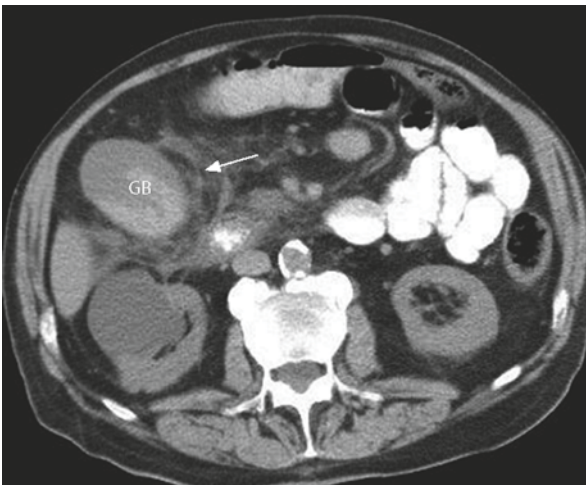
CT scan through the upper abdomen shows a distended thick-walled GB with marked pericholecystic stranding (*arrow*) suggestive of acute cholecystitis
